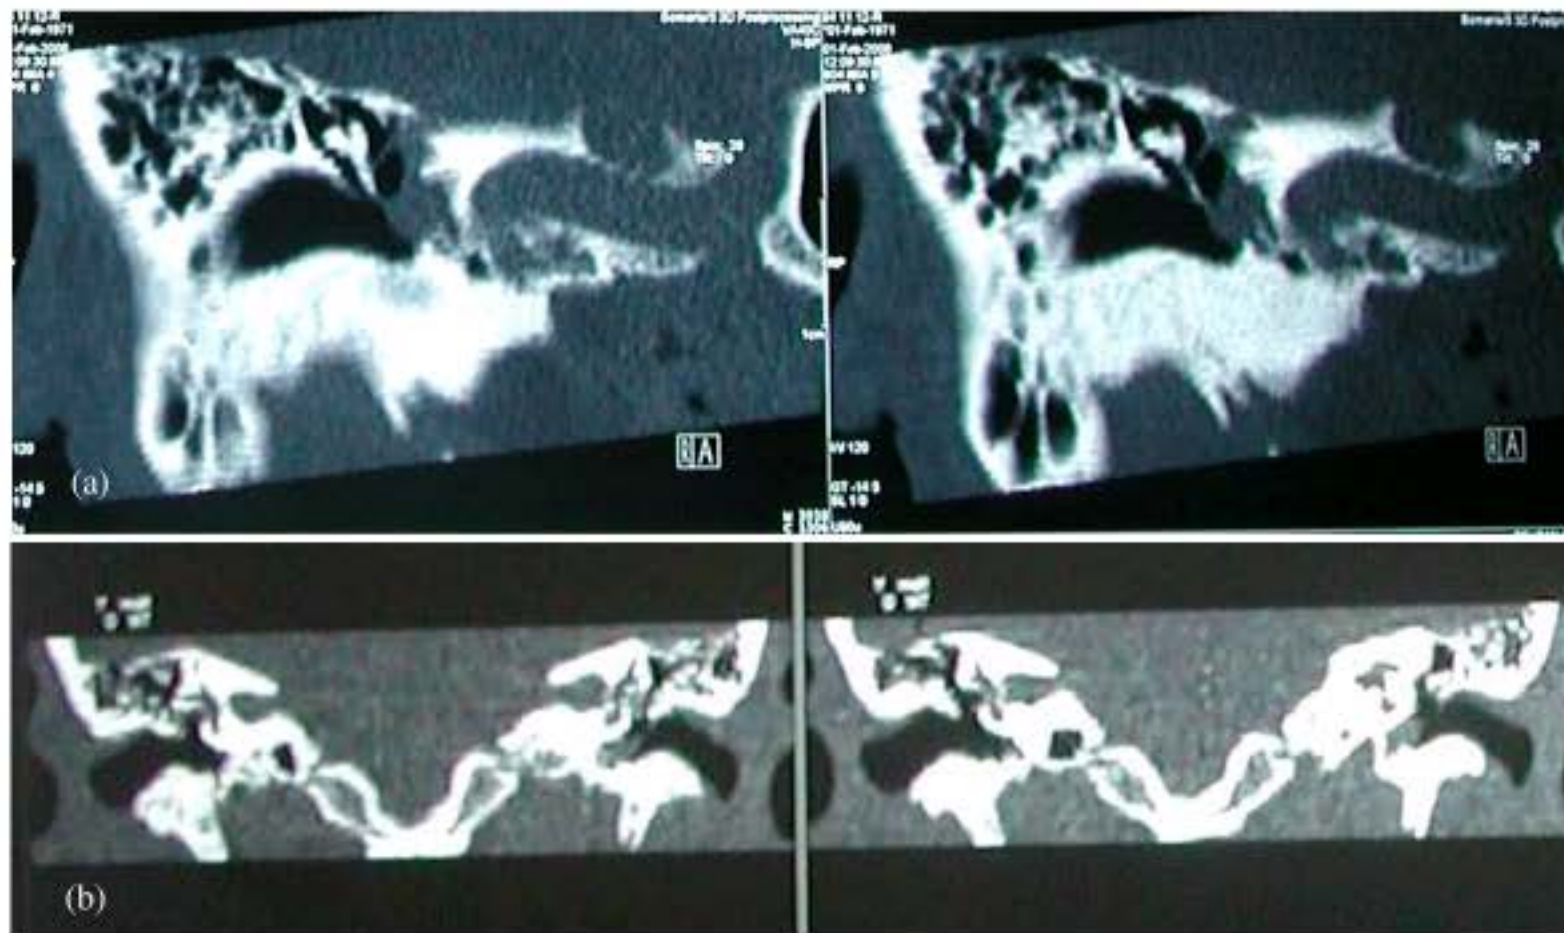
(a) CT scan of temporal bone showed a soft tissue density that is noted in right middle ear which creating a small air-fluid level foci suggesting otitis media in right side. (b) CT scan of temporal bone (Coronal view)
